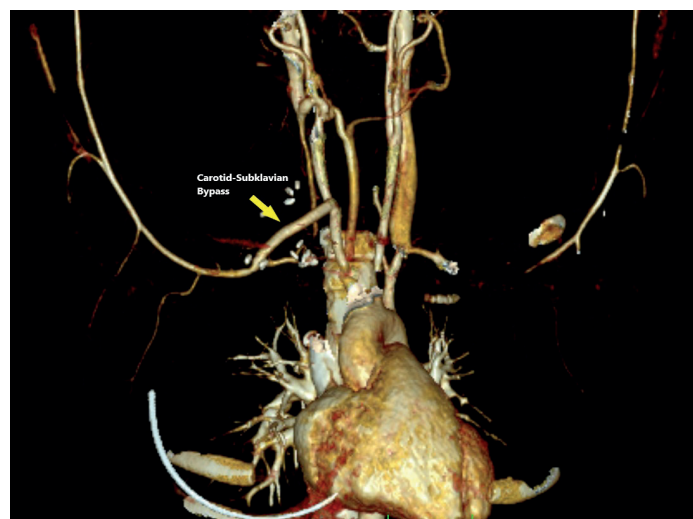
Carotid-Subclavian bypass (PTFE graft) CT angiography image
